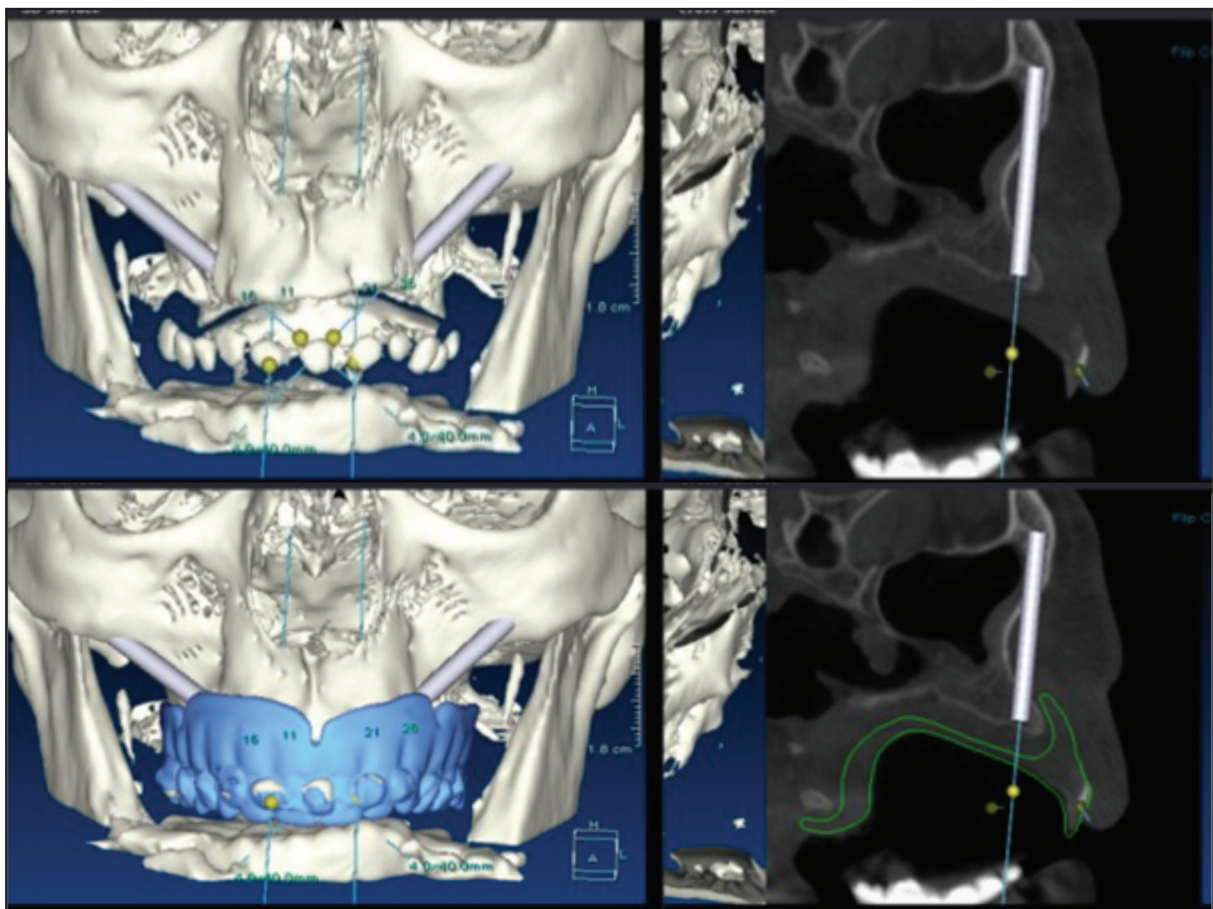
Showing different views and steps for the implant planning in the software by inserting the appropriate size implant and checking its position surgically as in Fig a and prosthetically as in fig b by checking its position in the bone in different sections and also with the help of the denture already merged in the CBCT
